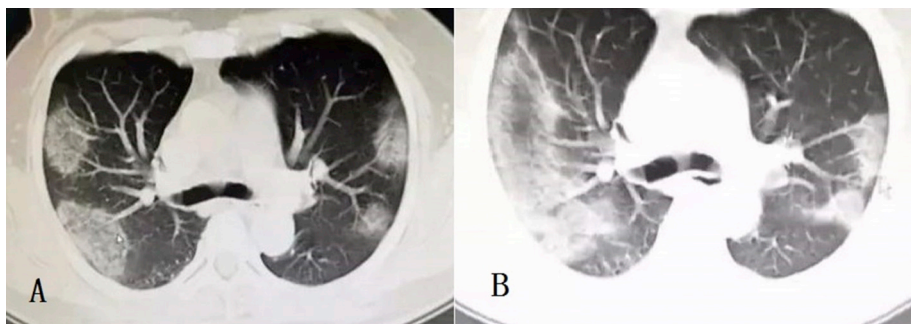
Chest CT imaging of the patient.
